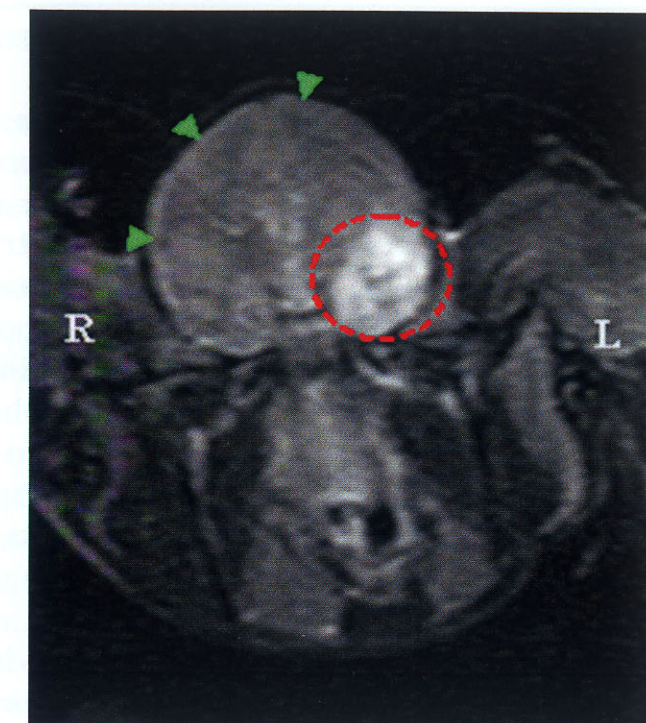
Postsurgical coronal FLAIR MRI sequences (slice locations: left—L, right—R) confirm onset of ischemia (*dotted circle*) in the left temporal and inferior frontal lobe following the production of a period of left MCA occlusion. Images also confirm the presence of subarachnoid hemorrhage (indicated by *green arrowheads*)
